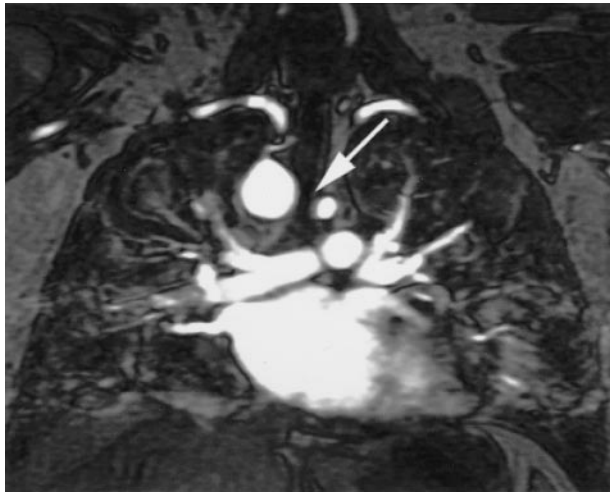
MRI of vascular entrapment of the trachea. The arrow refers to the narrowed segment.
